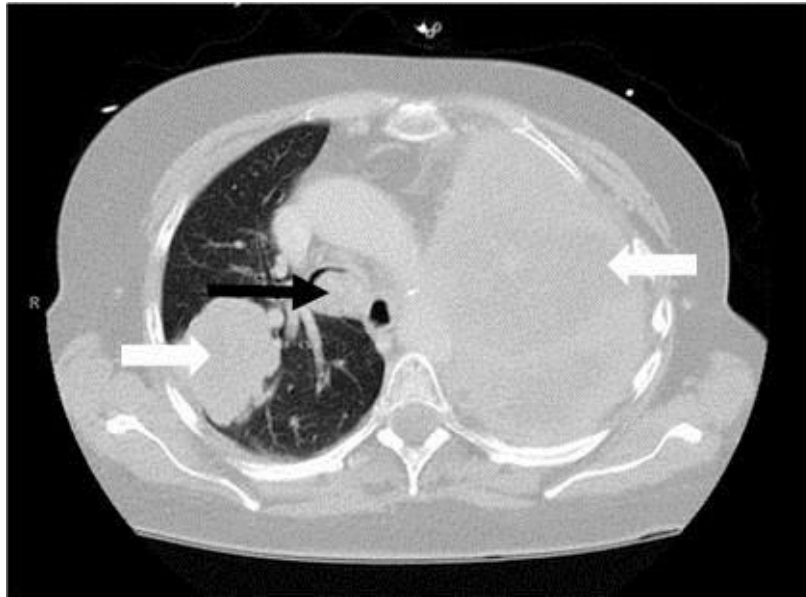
CT scan of the chest shows bilateral masses (white arrows), left sided pleural effusion and endobronchial mass (black arrow).
